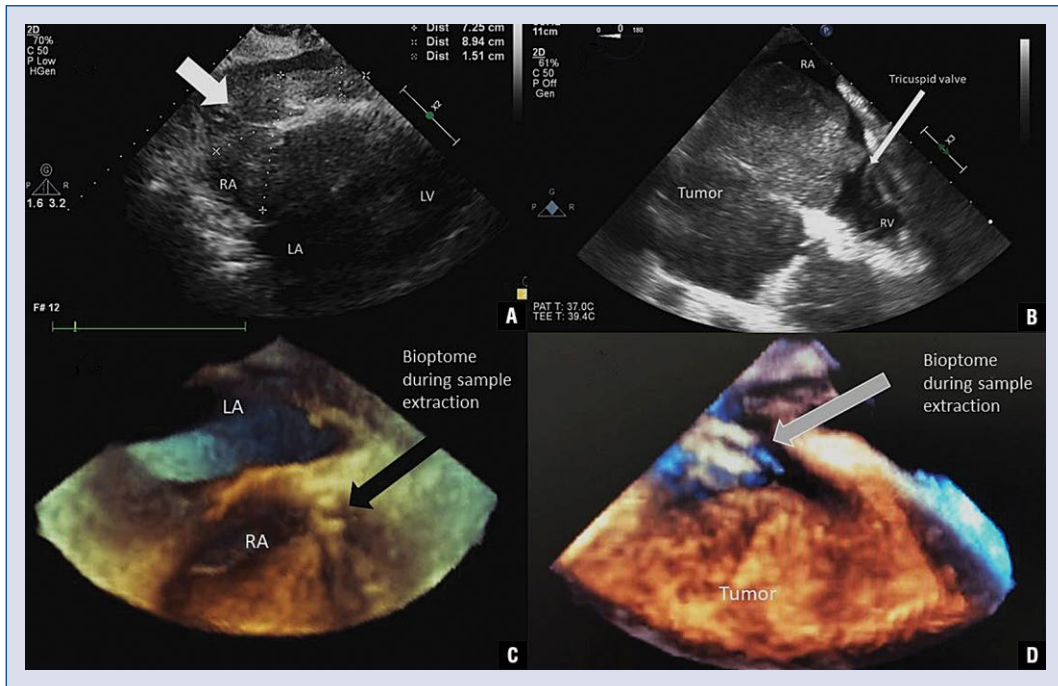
Imaging of the tumor; A. Large tumor with heterogeneous echogenicity (shown with a white arrow) infiltrating the wall of the right atrium (RA) and filling its cavity almost completely, visible from the substernal view in transthoracic echocardiography; B. Visualization of relation between tumor and tricuspid valve in transesophageal echocardiography (TEE); C, D. Three-dimensional TEE imaging showing exact localization of bioptome during extraction of tumor tissue samples; LA — left atrium; LV — left ventricle; RV — right ventricle.
